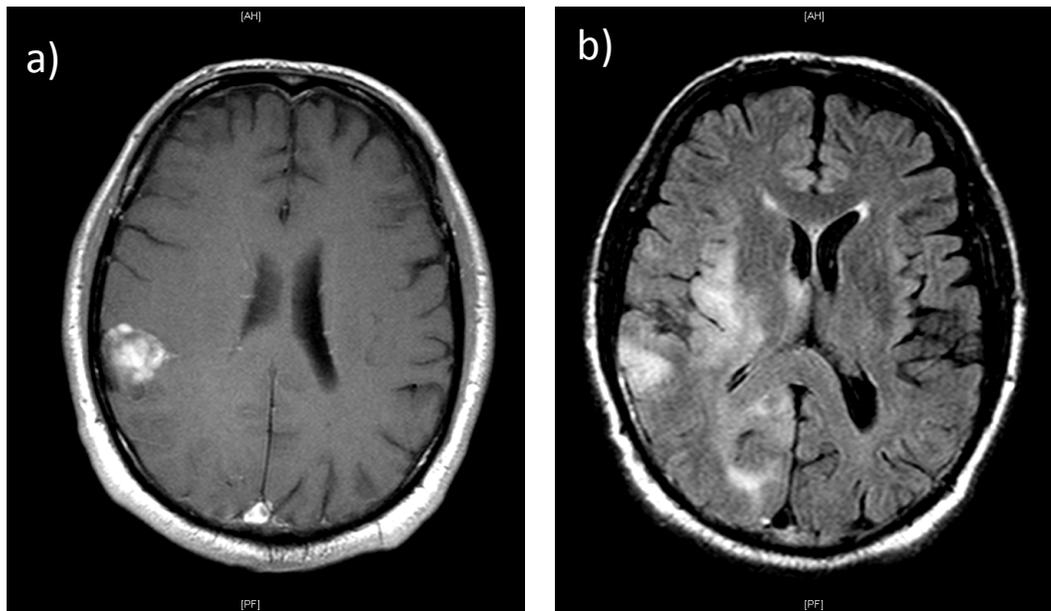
Brain MRI of the patient at diagnosis
